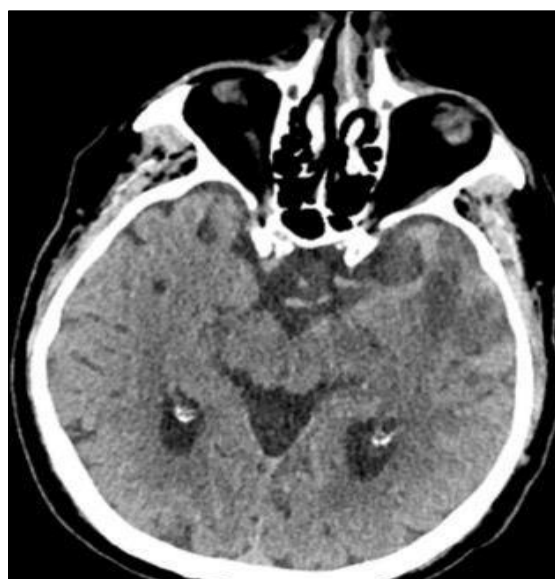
Follow-up brain CT scan
